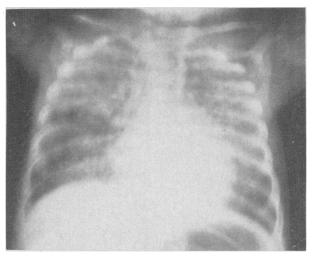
Chest radiograph of Case 12, showing finely mottled appearance of the lung parenchyma and presence of peripheral emphysema.
